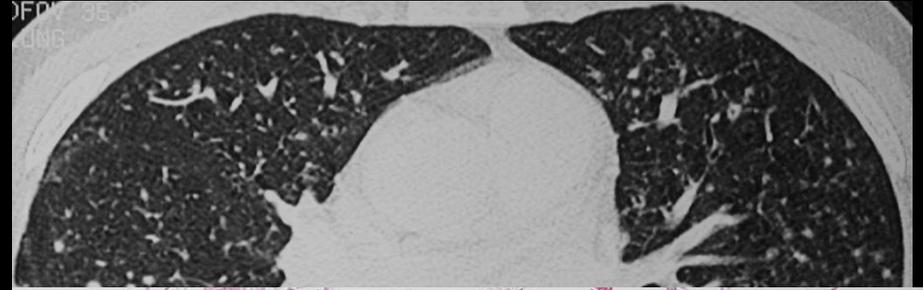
Abbot Radiographics 2005
